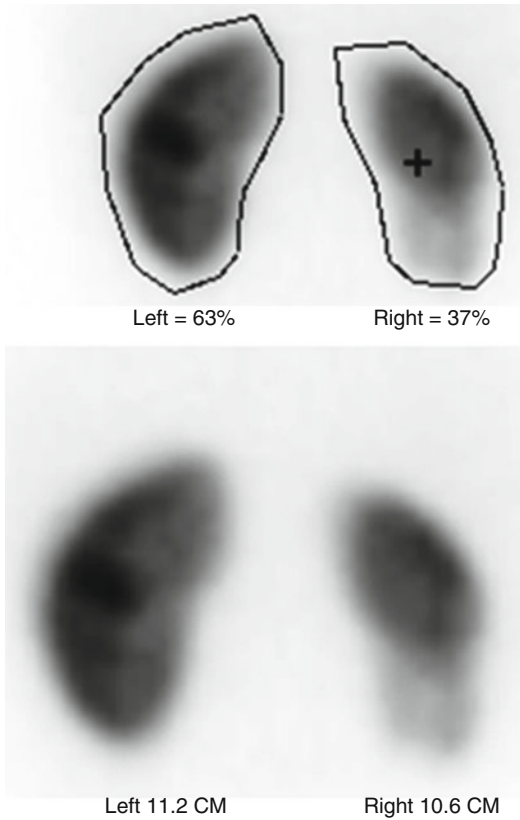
When performing renal cortical scintigraphy, it also is possible to determine differential (split) renal function and to measure renal size
